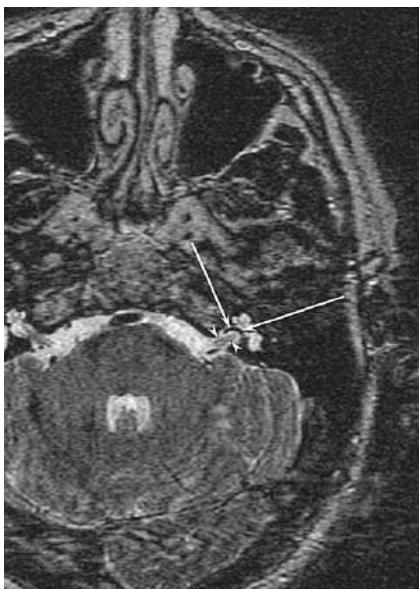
Vascular loop. High-resolution axial T2-weighted MR image demonstrates a curvilinear signal void (arrows) deep in the IAC, near the base of the cochlea. This represents the anterior inferior cerebellar artery extending into the IAC. The artery can be distinguished from the nearby nerves (arrowheads) by the complete lack of signal in the artery, and its curved course
